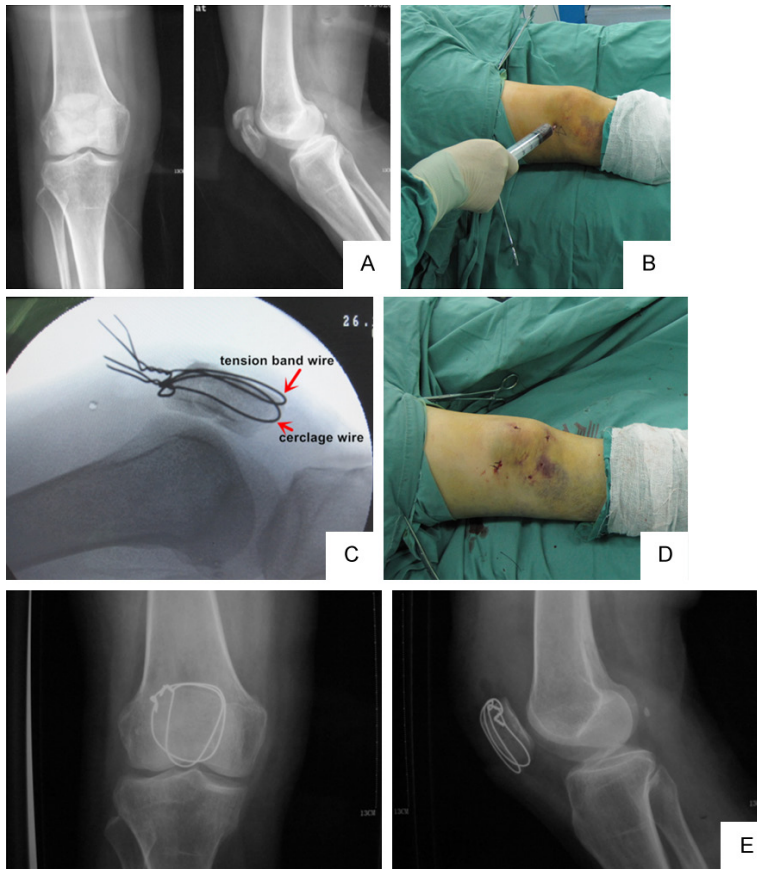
Patient, female, 44 y, traffic accident, right comminuted patellar fracture, AO C2.1. A. A preoperative AP and lateral view radiograph shows the comminuted patellar fracture. B. The bundling wire was fixed first, and then the articular was pry-poked repositioned by the K-wire under minimally invasive technique. C. Fixation by the K-wire and the lateral view and axial view to judge the articular surface. D. Incision: only 3 longitudinal incision and 3 puncture points. E. AP and lateral view post-operation. F. AP and lateral view when the fracture was united.
